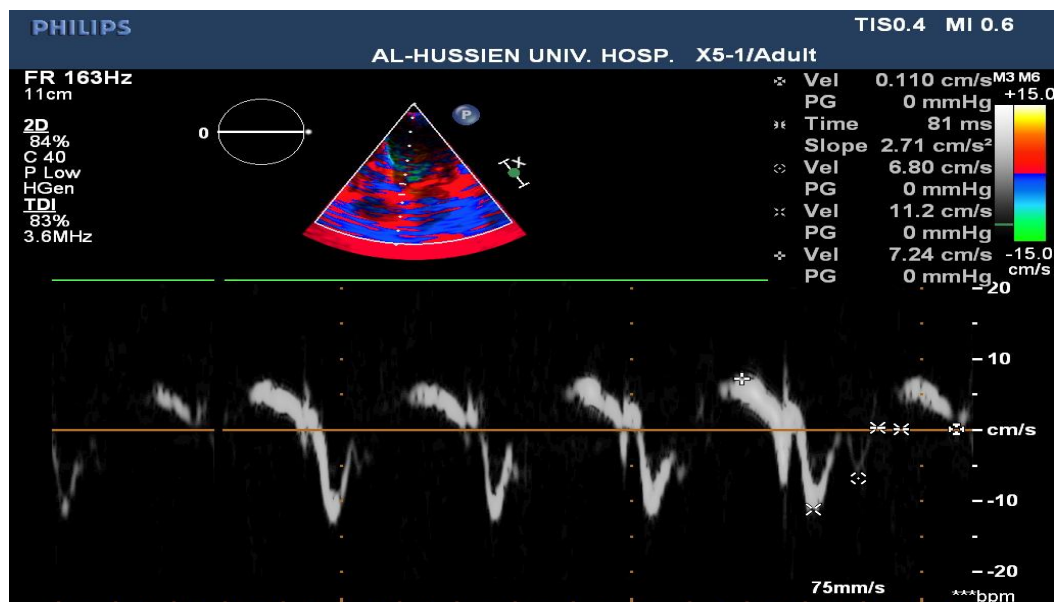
TDI mitral valve septal annulus (Em: 11.2 cm/sec), Am (6.5cm/sec), Sm (7.2cm/sec), E/E'(7.7) Normal tissue Doppler image parameters. Patient No. (19) with mild asthma
